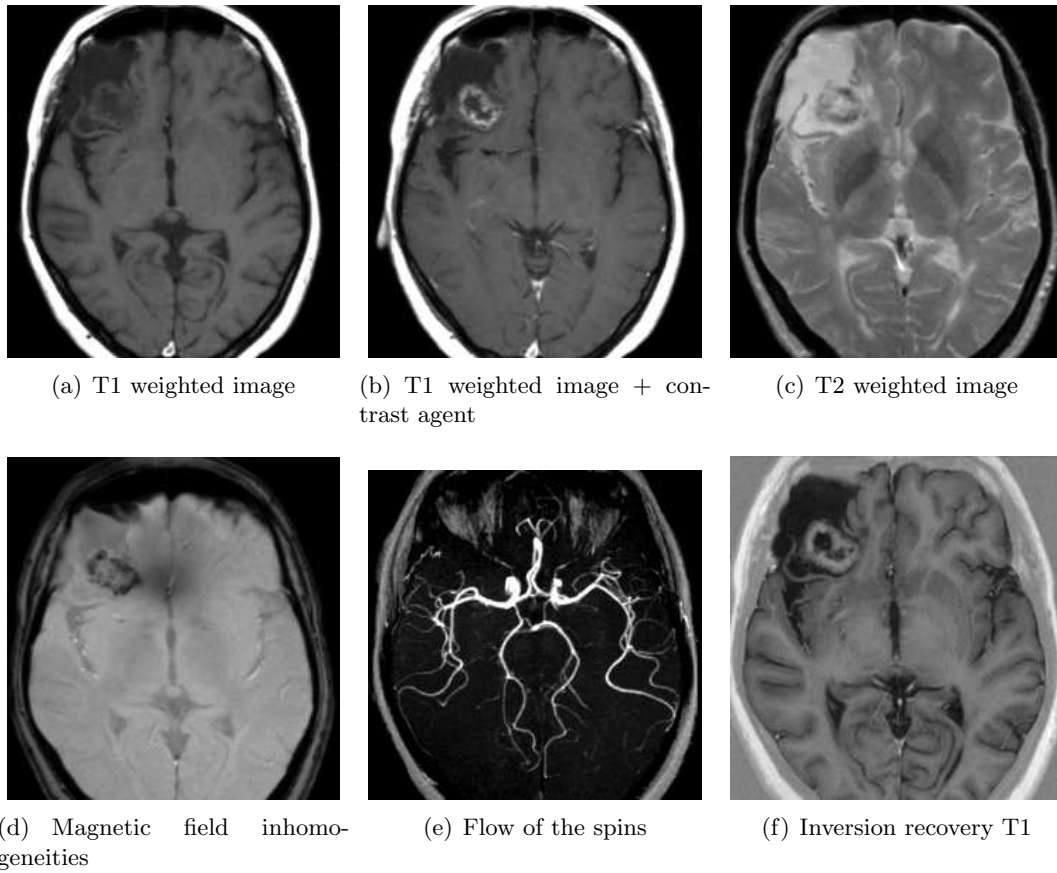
Examples of image contrasts in MRI. Only in the mid upper image, the external contrast agent (extracellular, Gd chelate) was administered.
